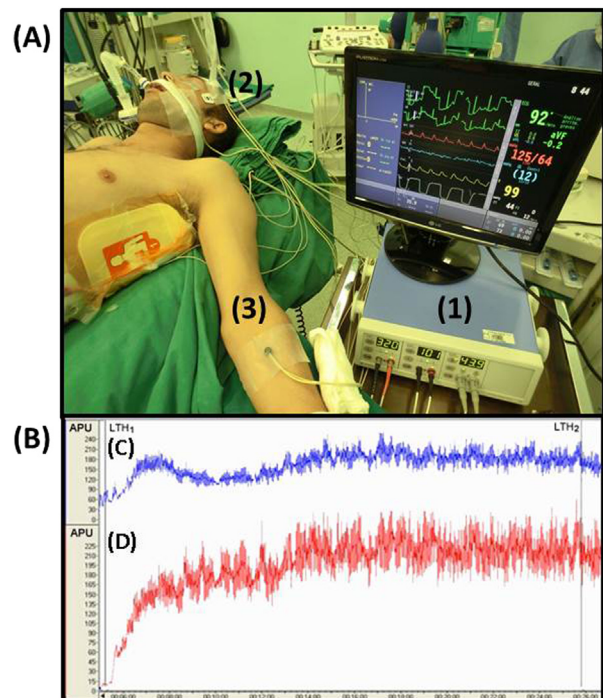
Picture of the experimental setup used to assess skin microvascular perfusion using laser Doppler perfusion monitoring (A). A representative example of the effects of heating on skin microvascular blood flow (B) in the forearm (C) and the forehead (D). (1) Laser Doppler unit, (2) forehead heating probe, (3) forearm heating probe (see methods). APU, arbitrary perfusion units; LTH₁: start of local thermal hyperemia; LTH₂: end of local thermal hyperemia.
